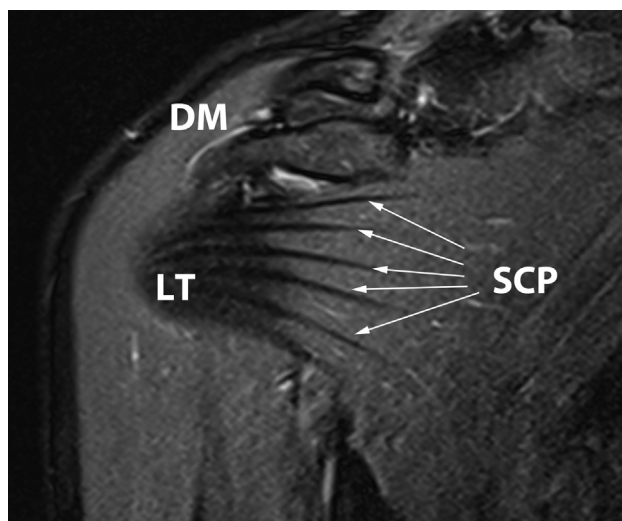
T2-weighted magnetic resonance imaging scan of a right shoulder in the frontal plane just at the level of the lesser tuberosity (LT). The subscapularis tendon (SCP) inserts with horizontally orientated strong fibers at the LT. (DM, deltoid muscle.)
